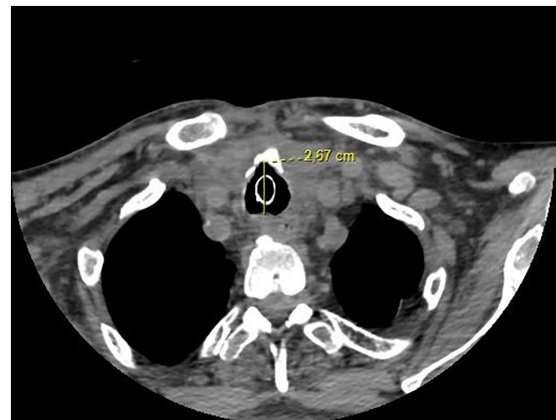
Computed tomography of the neck after total thyroidectomy operation. The tracheal lumen diameter was 2.67 cm.
